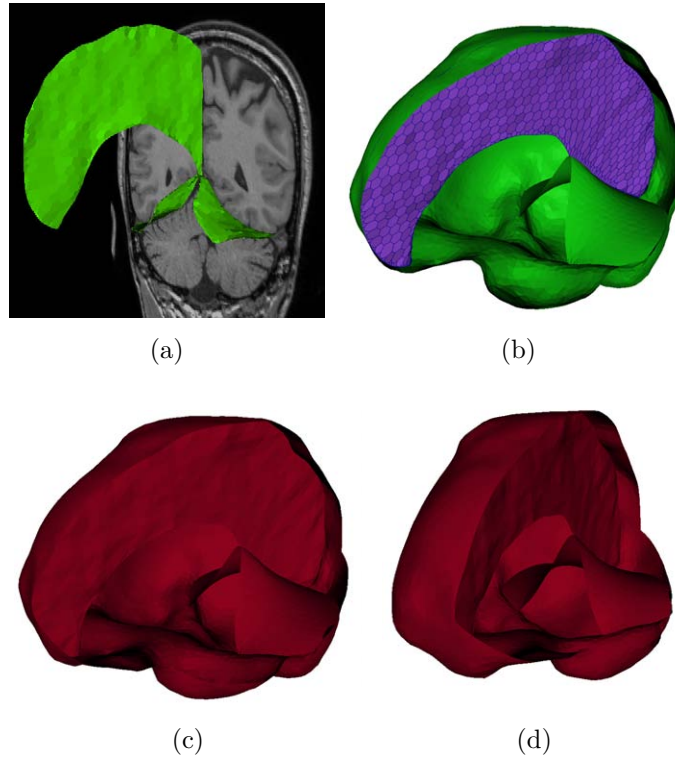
(a) Tentorium and falx mesh deformed in an MRI image. (b) Falx mesh deformed inside the mesh \mathcal{M}_{ST} (green). Mesh \mathcal{M}_{ST} is cut to allow visualization. (c) Falx mesh transformed into a triangulation and joined with \mathcal{M}_{ST} . (d) Same mesh from another point of view.
